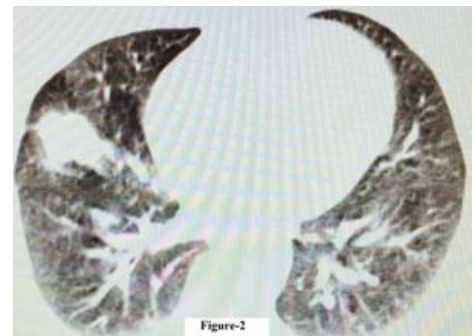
Computed tomography revealing the mass in the middle lobe of the right lung
